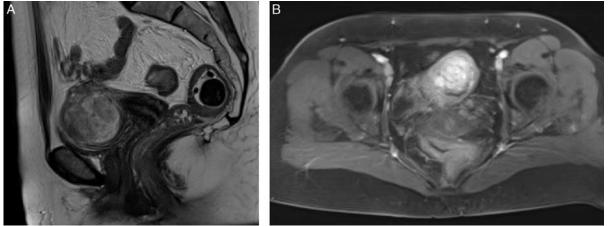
The MRI revealed a voluminous myometrial fundic mass broadly protruding in the uterine cavity. (A) Sagittal magnetic resonance imaging slice. (B) Axial magnetic resonance imaging slice with contrast.
